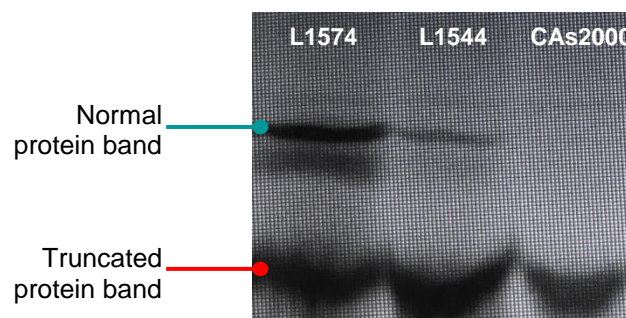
Partial radiography from the PTT, representing the normal and the truncated protein bands for 3 samples: L1574, L1544 and CAs2000.
